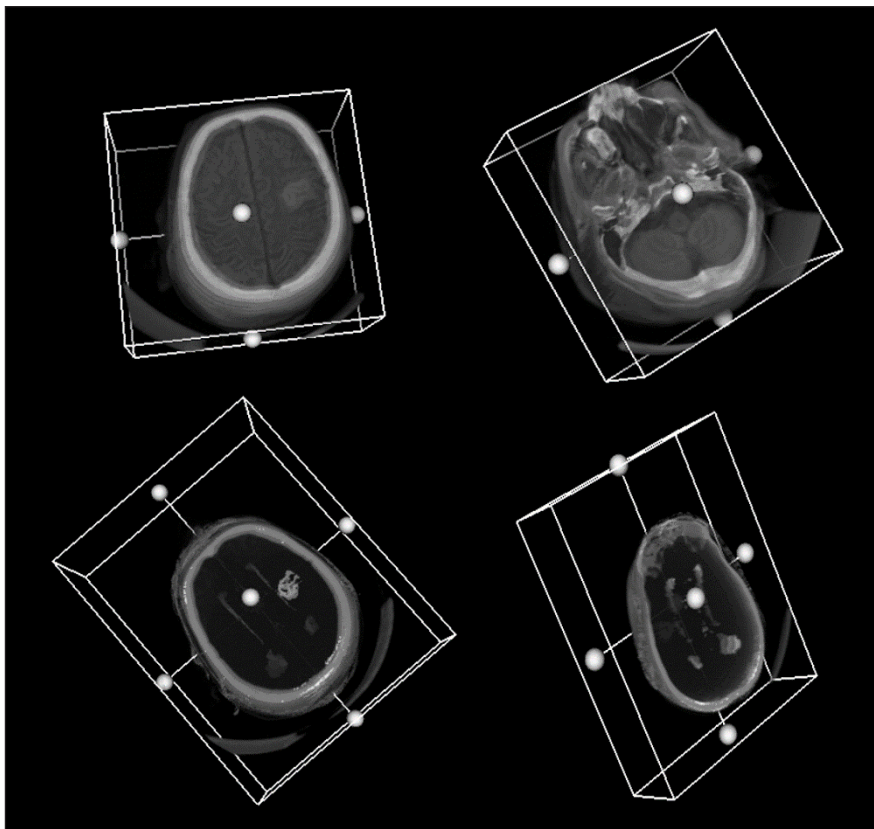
Resultant of feature-based fusion shown at rightmost image demonstrating CT bone window, soft tissue from registered MRI and lesion extracted from Otsu multiple thresholding technique. From left is the CT, registered MRI, and resultant of Otsu multiple thresholding technique respectively.
